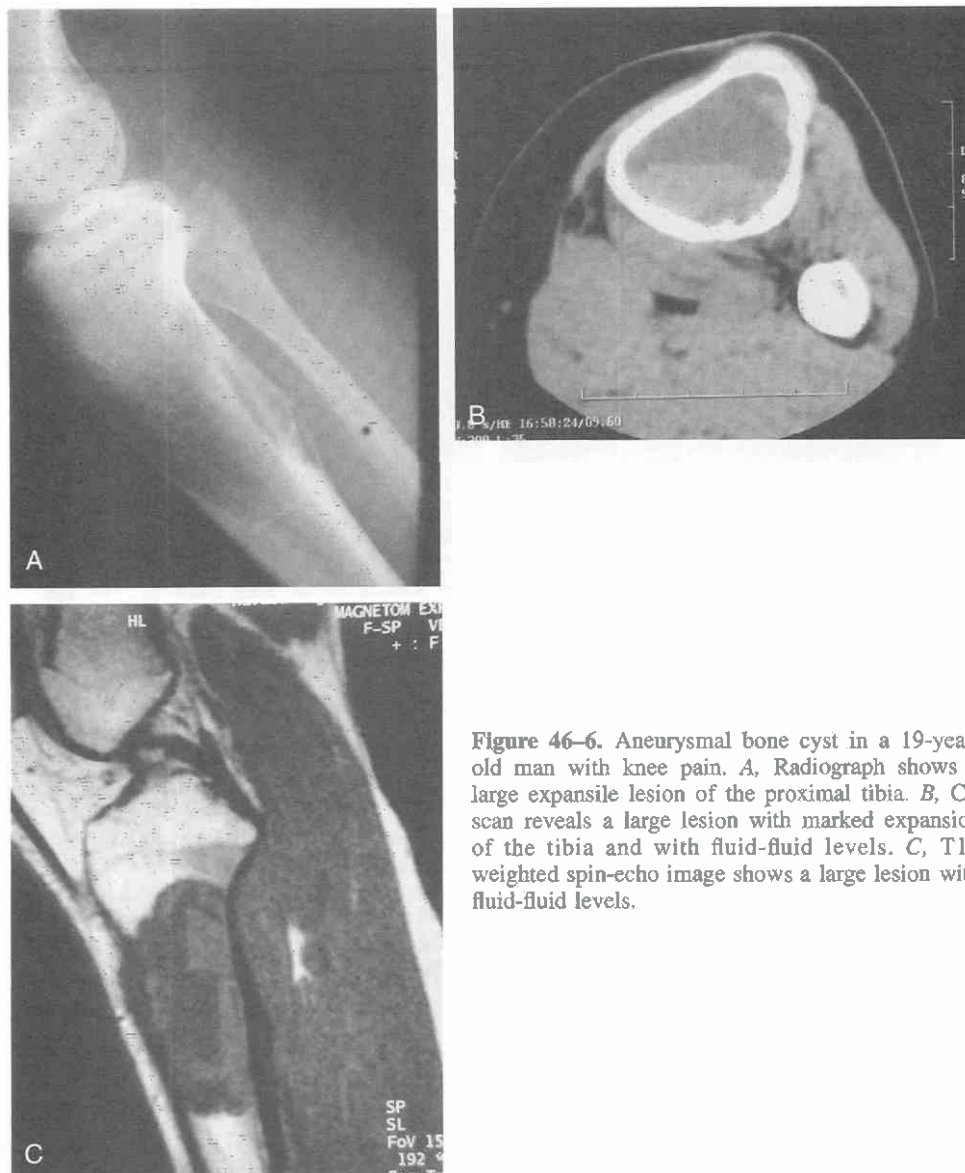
Aneurysmal bone cyst in a 19-year-old man with knee pain. A, Radiograph shows a large expansile lesion of the proximal tibia. B, CT scan reveals a large lesion with marked expansion of the tibia and with fluid-fluid levels. C, T1-weighted spin-echo image shows a large lesion with fluid-fluid levels.
